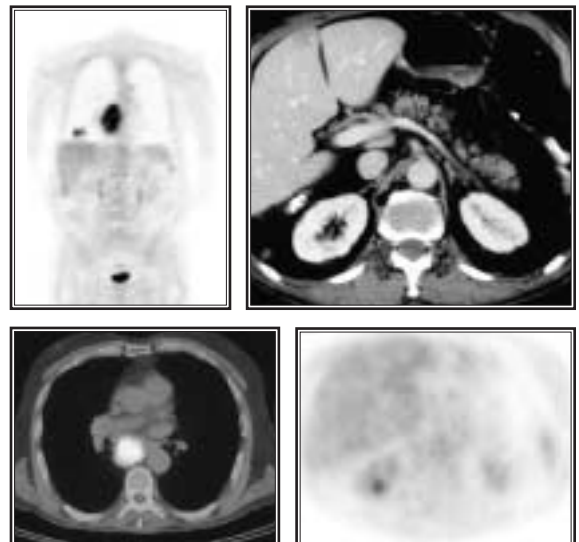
81-year-old man with SCLC for initial staging. PET/CT shows uptake in right lung and mediastinum. CT shows lesion in liver. PET/CT allows accurate fusion to exclude disease in liver and adrenals. Disease is confined to left hemithorax.
